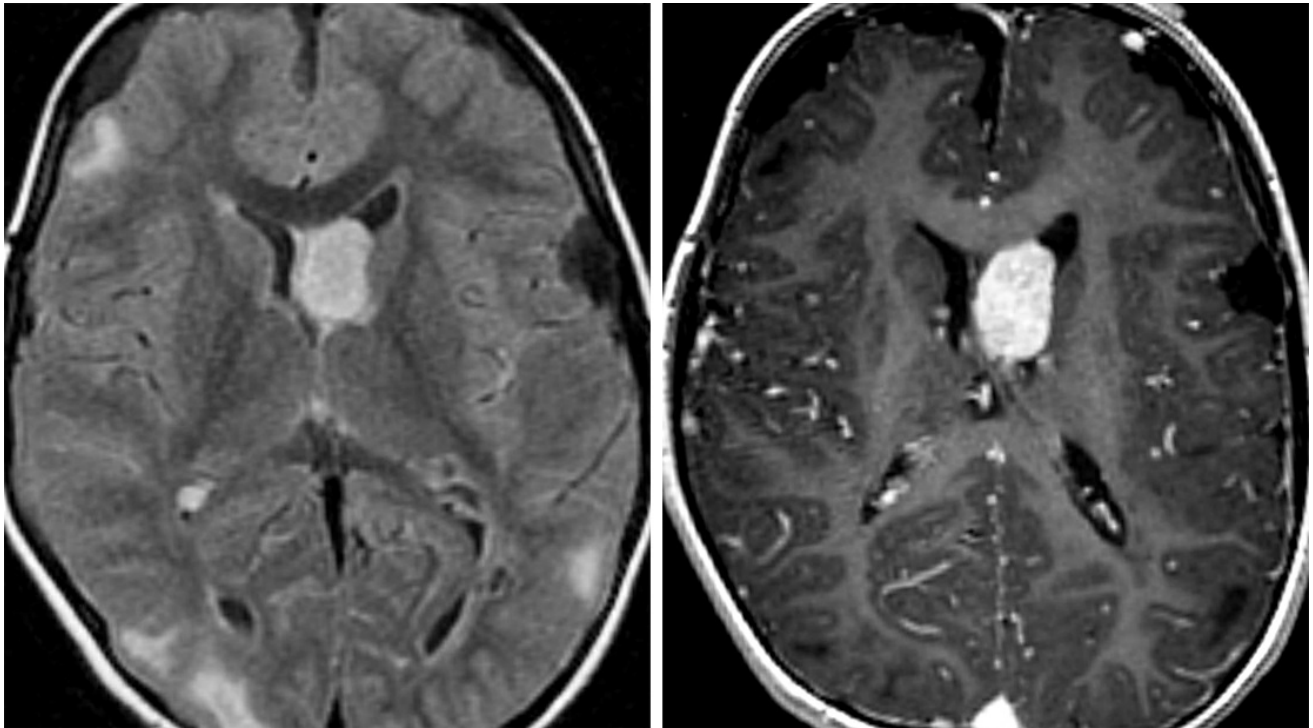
This subependymal giant-cell astrocytoma (SEGA) is present in its typical location at the foramen of Monro. This lesion is larger than should be seen for other subependymal nodules in tuberous sclerosis. (Left) A FLAIR image demonstrates multiple subcortical hyperintense tubers. A hyperintense right posterior periventricular nodule is also visible. Other calcified subependymal nodules are less evident. (Right) Postcontrast T1WI demonstrates the avid enhancement typical of SEGAs.
